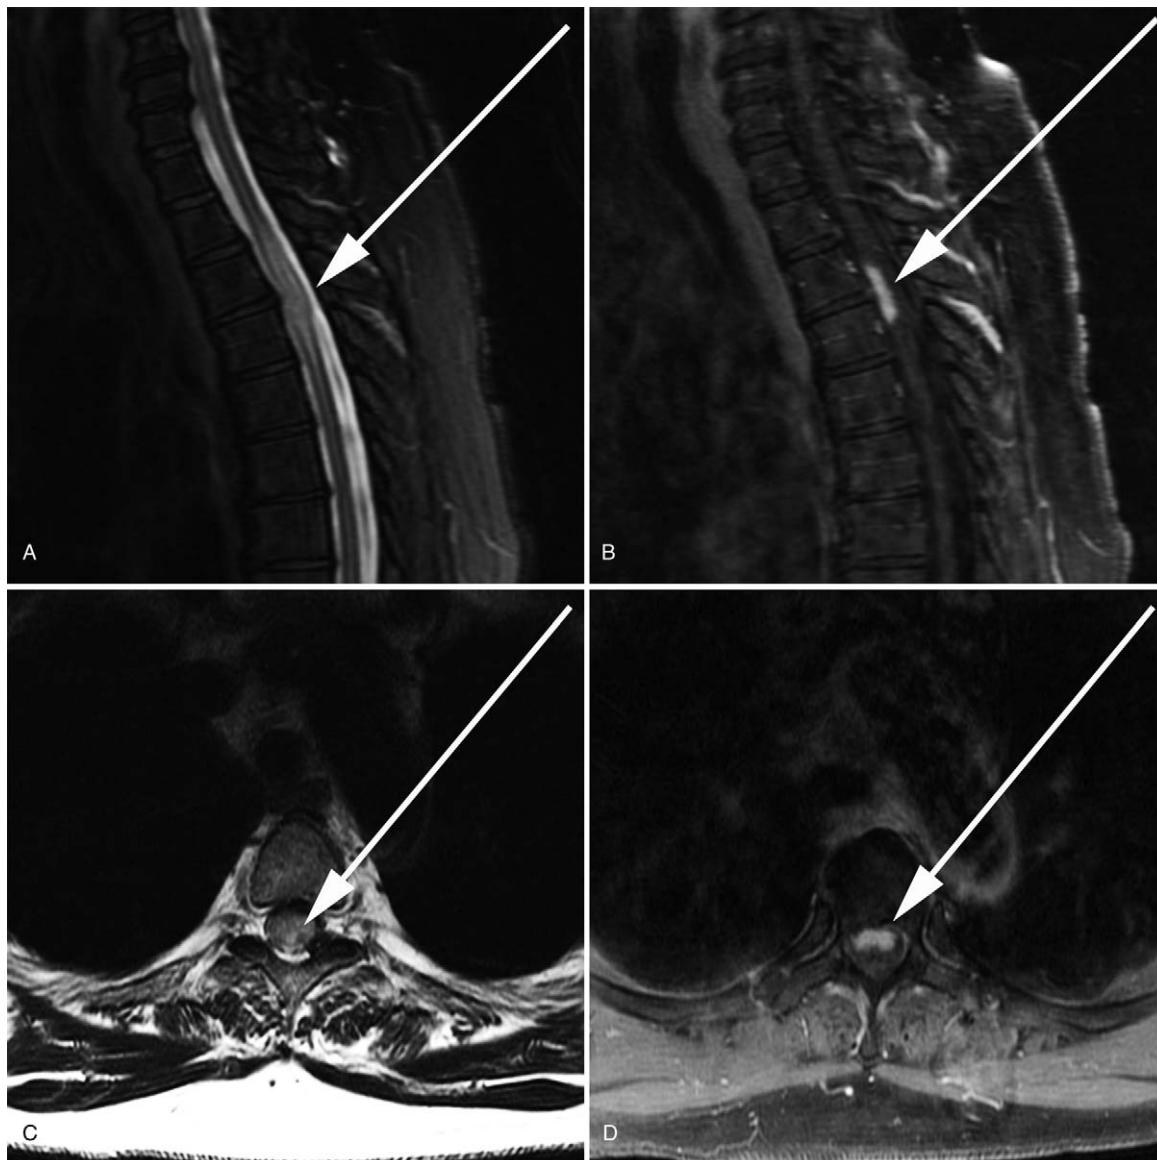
A 69-year-old woman with spinal sarcoidosis who initially presented with lower extremity weakness. MRI of the spine revealed a slightly distended T2 hyperintense abnormality predominantly affecting the ventral aspect of the mid-thoracic spinal cord (A and C). Postcontrast imaging (B and D) revealed corresponding irregularly bordered enhancement involving the bilateral ventral aspects of the cord. FDG PET CT anterior projection MIP image of the chest (E) displays bilateral hilar and paratracheal hypermetabolic lymph nodes. One-hour post-FDG injection (F) PET imaging displays hypermetabolism corresponding to the area of abnormal cord enhancement with a maximum SUV of 4.7. The degree of hypermetabolism significantly increases on 5-hour postinjection imaging with a maximum SUV of 14.0 (G).
